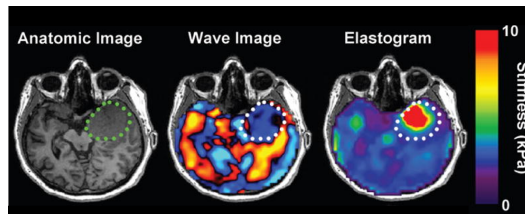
MRI and MRE images of brain affected by meningioma [4]
